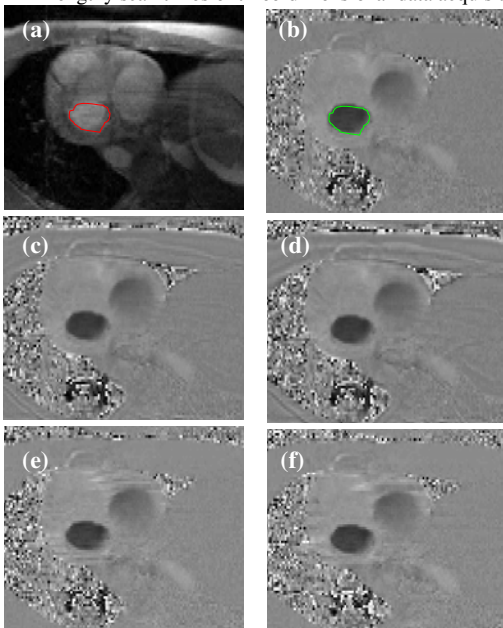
Single frames of MR images reconstructed showing magnitude image (a) with full phase-reference k-space data, and phase-velocity images with (b) full phase-reference k-space data, (c) 50% phase-reference k-space data, (d) 33% phase-reference k-space data, (e) temporal view-sharing acceleration factor of 3, and (f) temporal view-sharing acceleration factor of 7.
